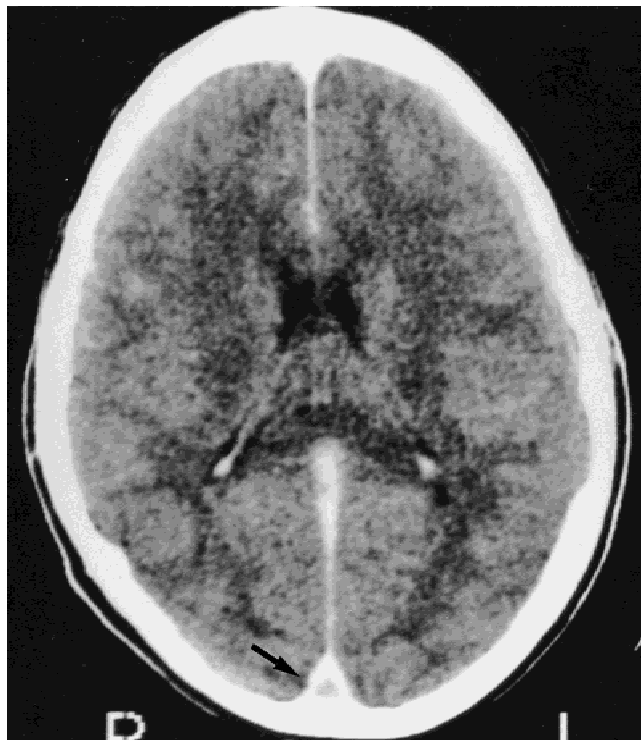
CT scan of patient number 2, made 3 days after onset of symptoms, clearly showing the empty delta sign after contrast administration (arrow).
